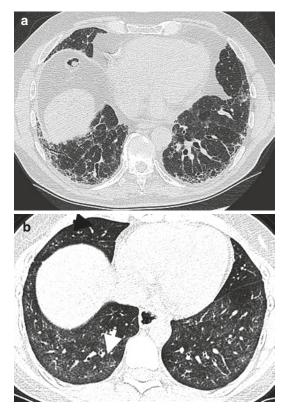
High-resolution CT chest (HRCT) in SLE. (a) Chronic fibrosis with honeycombing, subpleural thickening, and mild ground glass attenuation of alveolitis and traction bronchiectasis. (b) Different patient with features of NSIP on this axial high-resolution image with bilateral symmetrical ground glass opacities (*arrow*), more pronounced at the lung bases and sparing the subpleural zones
